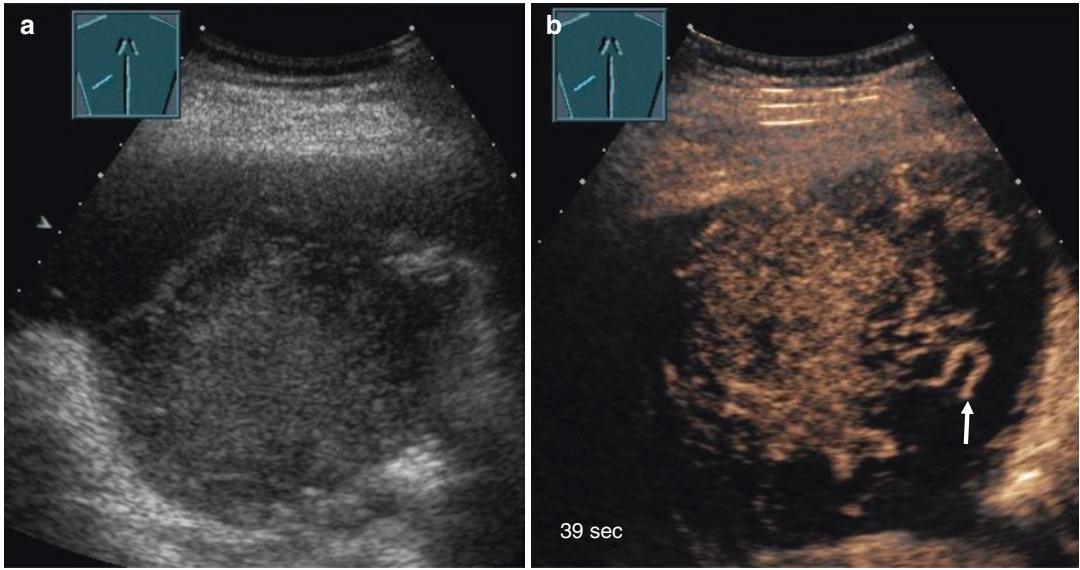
Peripheral malignant lesions with different patterns of bronchial arterial supply indicating different extent of tumor neoangiogenesis: B-mode ultrasound (left) and patterns of marked arterial supply in a patient with renal cell cancer and pulmonary metastasis (a1–3);
